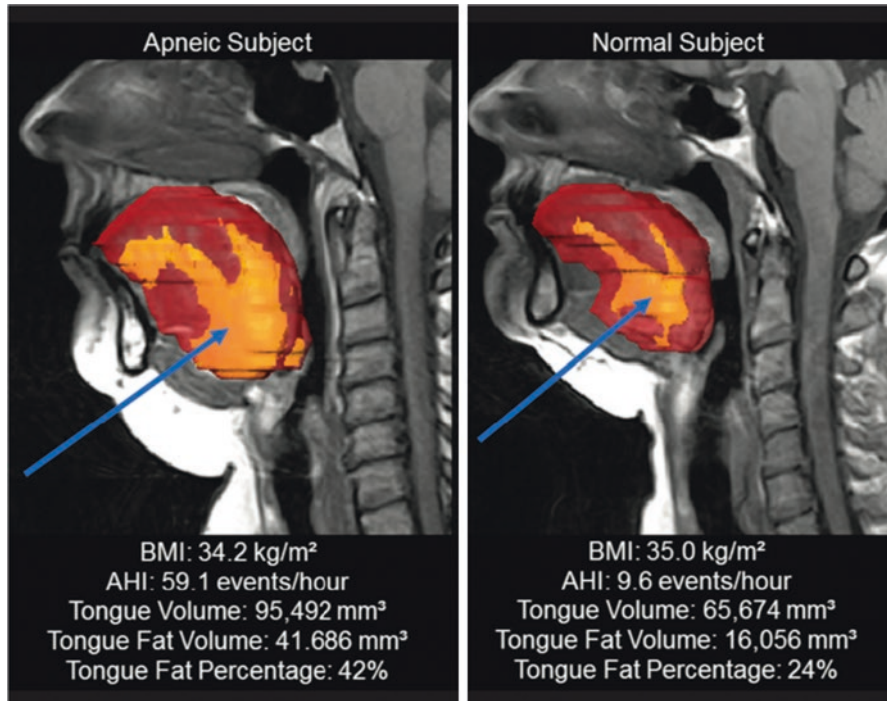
Tongue size/fat deposition. MRI cross section of a patient with OSA versus normal (non-OSA). Notice the shape of the tongue. Arrow points to fat deposition in the tongue. (Figure adapted from [14])
